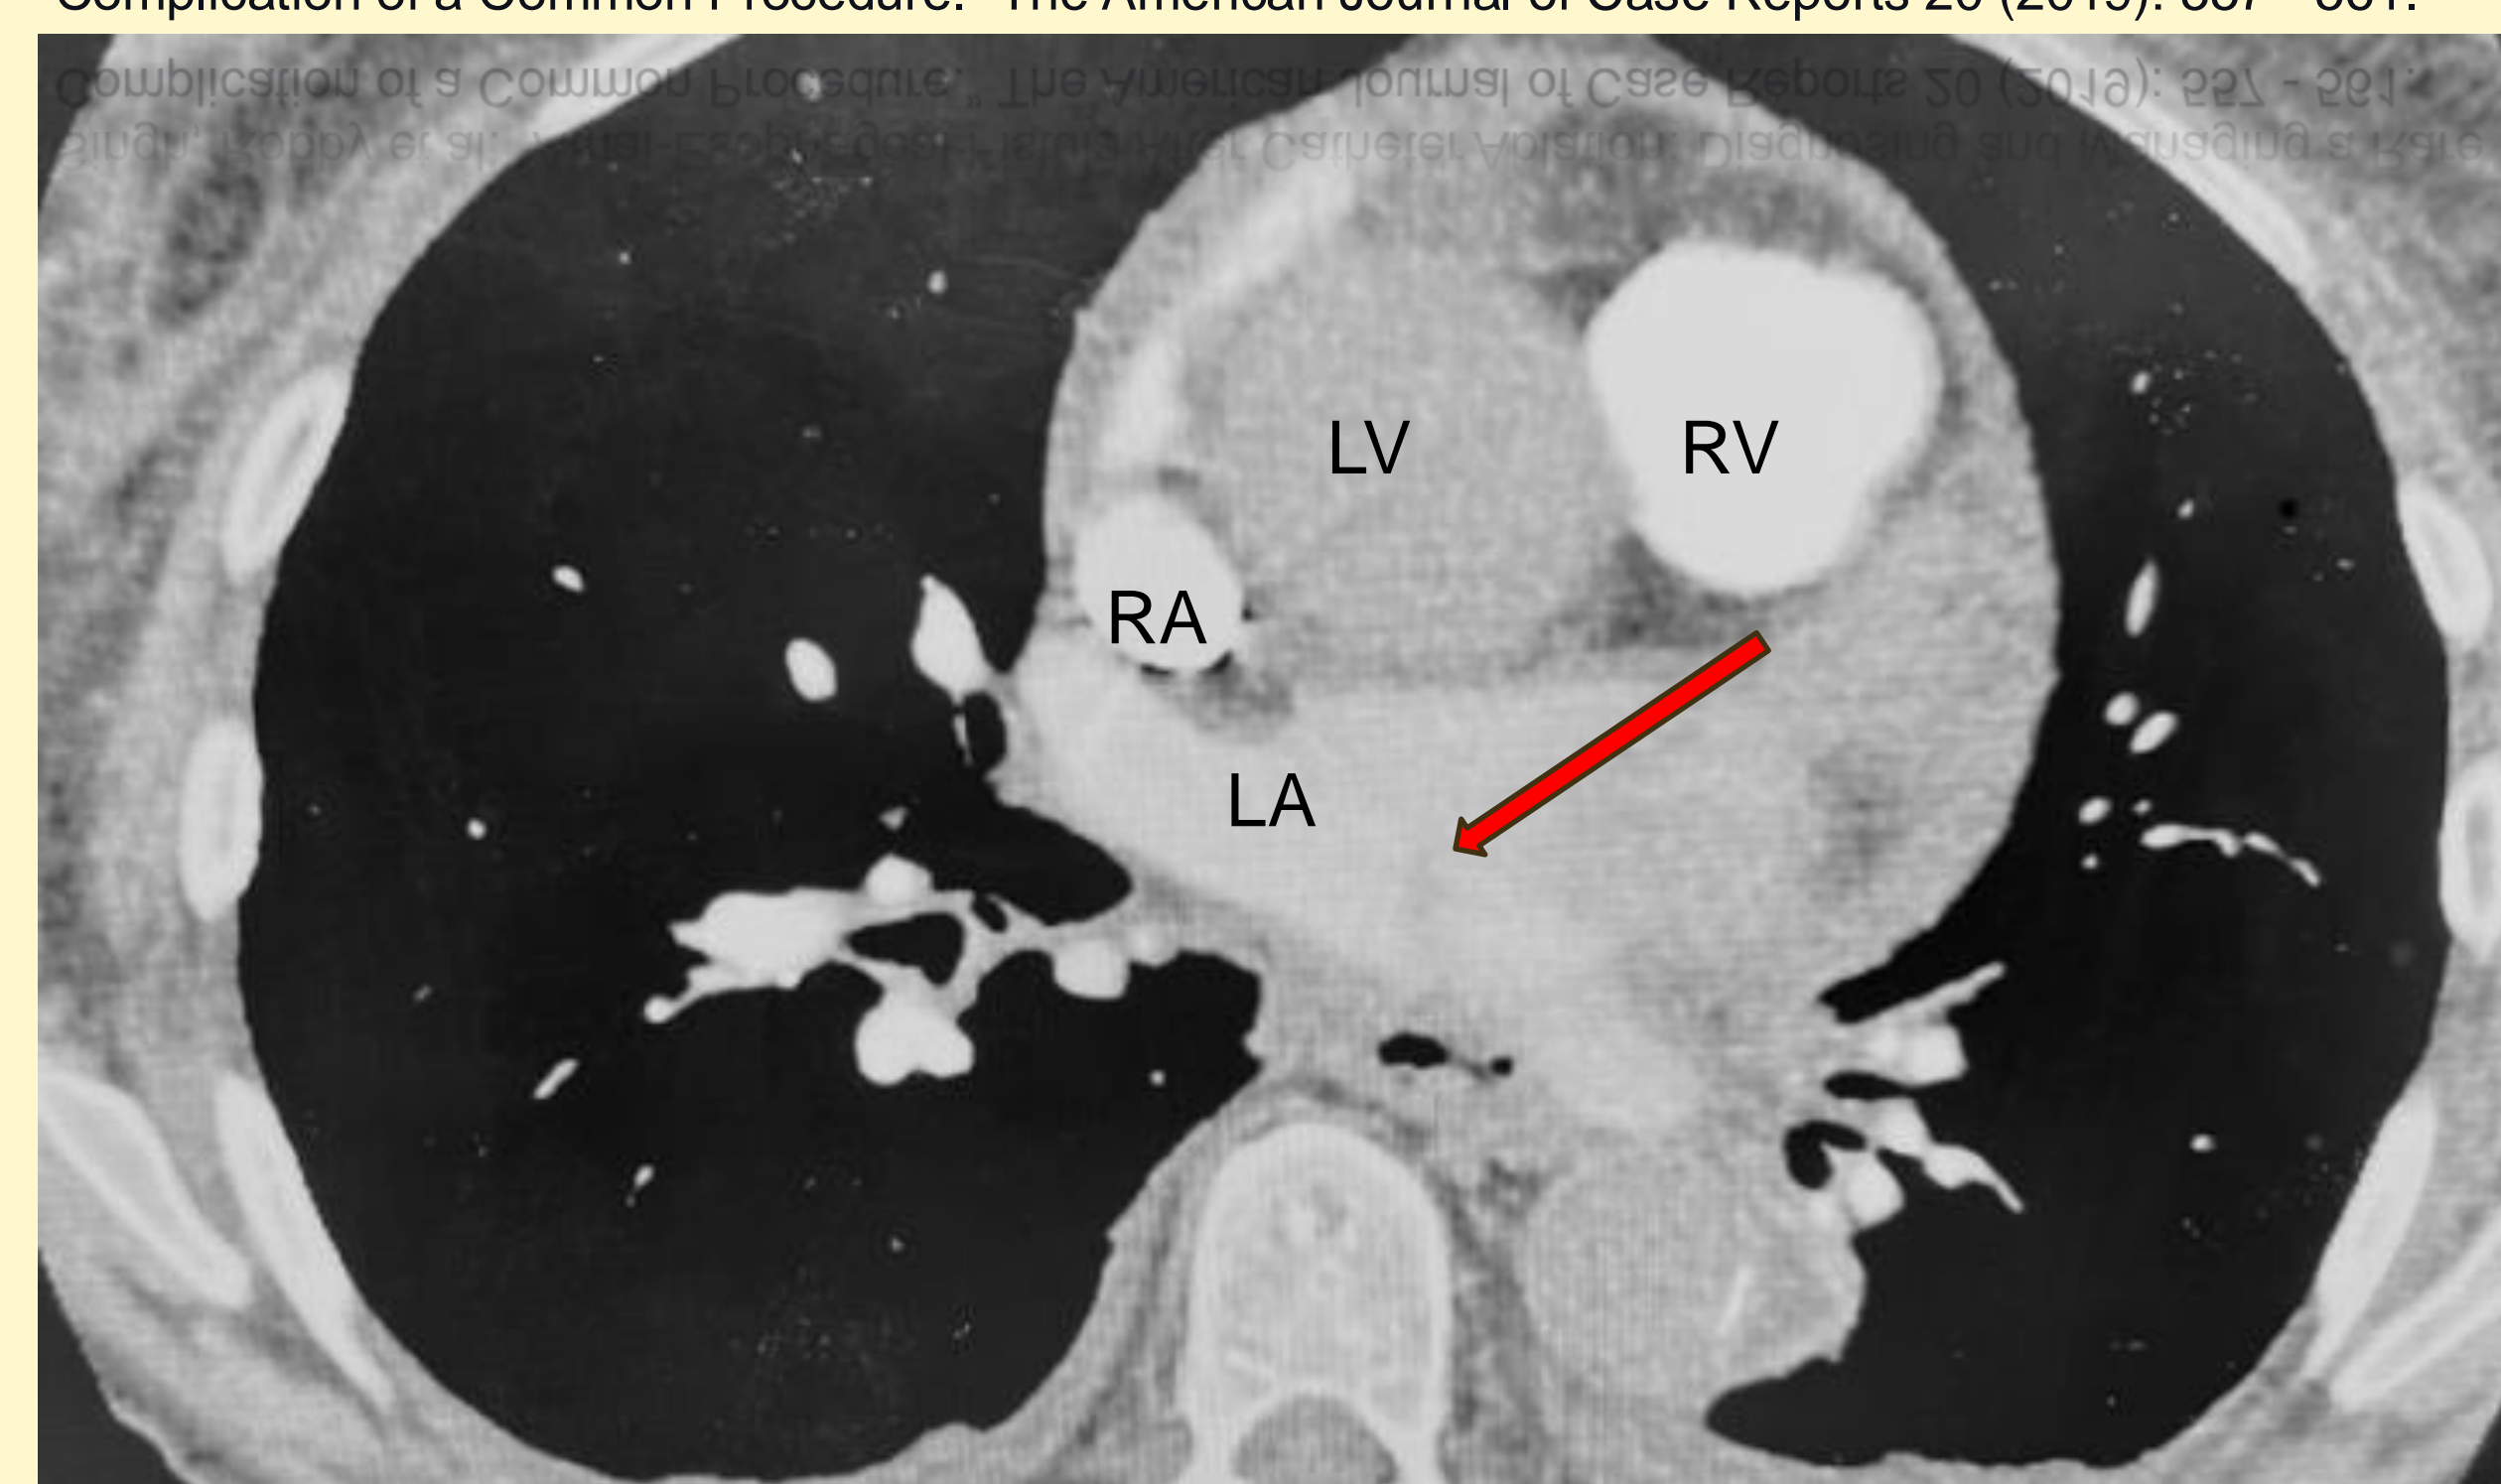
Patient CTA. The image shows intraluminal air at the level of the left atrium and pulmonary veins, with a faint tract (red arrow) suggesting a fistula.
